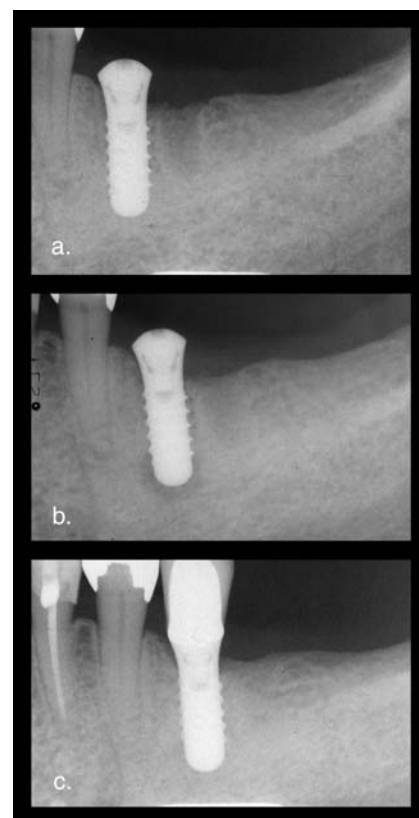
Patient NU, a 68-year-old woman. (a) An implant was inserted into the mesial root alveolus of a lower-left molar extracted 4 months earlier. (b) After 3 months, the site developed symptomatology (pain and swelling) and a radiograph disclosed a periapical radiolucency. The site was surgically debrided and disinfected and finally healed. (c) A 1.5-year postoperative radiograph.
